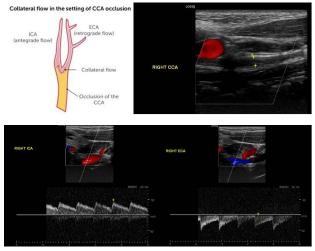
Sonographic images of retrograde flow in ECA and antegrade flow in ICA.
